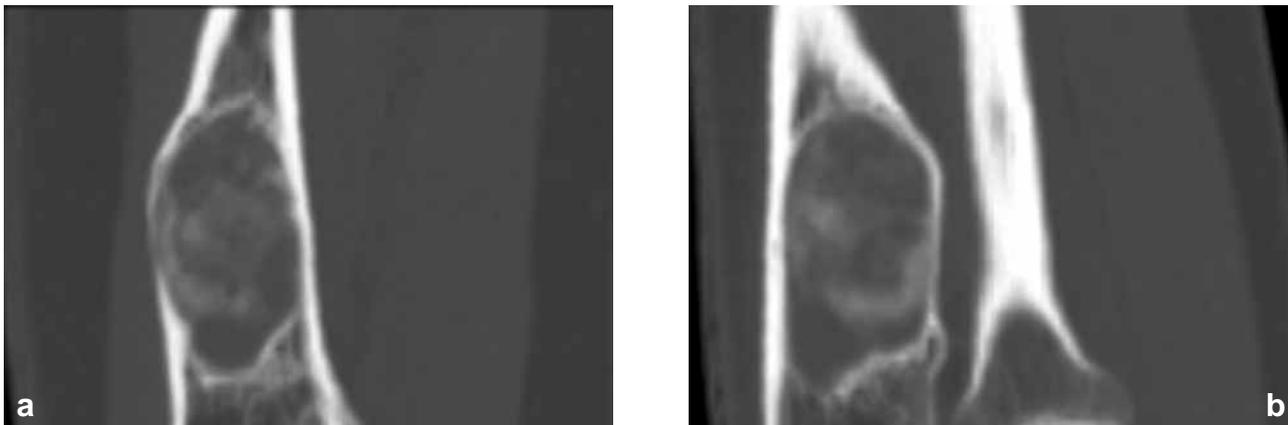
CT-scan with sagittal (3a) and longitudinal (3b) reconstruction images. The lesion is sharply demarcated with some attenuation of the cortex. Some mineralisation within the lesion can be seen.
